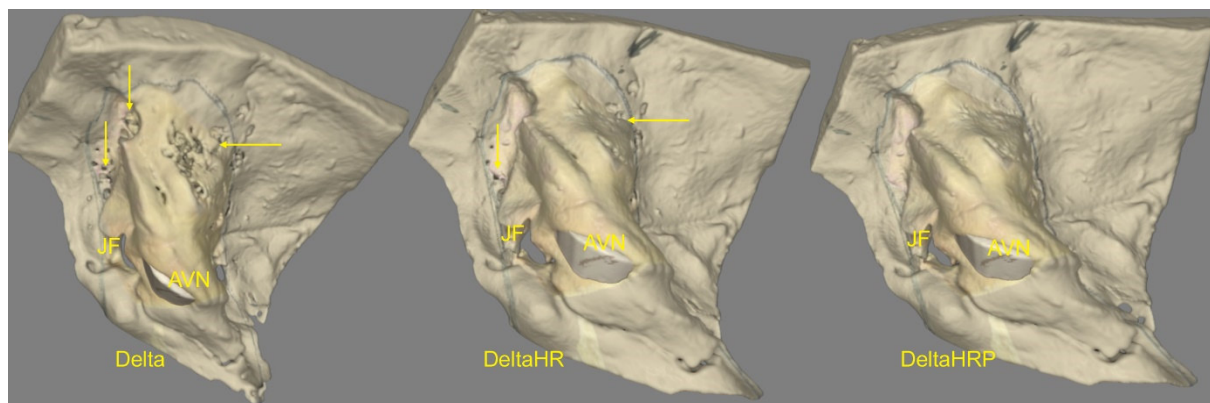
Different 3D reconstructions of the OpenEar dataset (Delta). Left: Model based on the clinical type CBCT + automatic smoothing routines. Middle: Model based on the high-resolution CBCT + automatic smoothing routines. Right: Model based on the high-resolution CBCT + automatic smoothing routing + manual postprocessing. Arrows mark bony defects (i.e. artefacts). Abbreviations: JF - jugular foramen, AVN - acoustic vestibular nerve.
